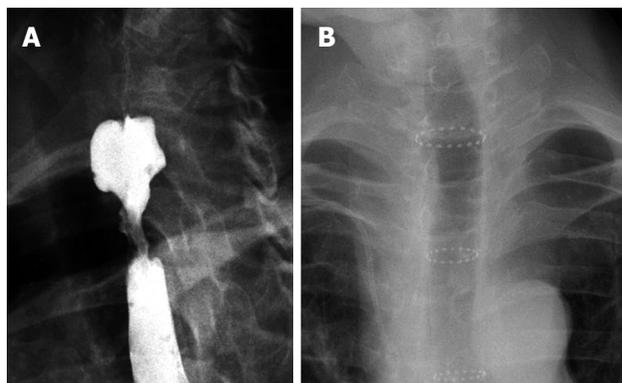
Radiograph of the stricture and Polyflex in the upper esophagus. A: Malignant stricture; B: Polyflex.
